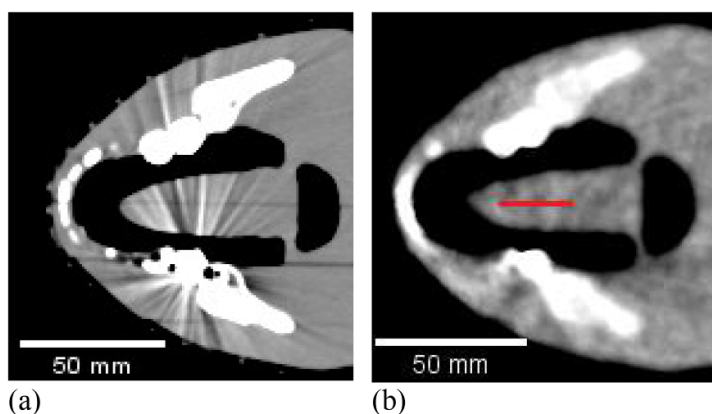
Close-up view, with enhanced contrast, of the tungsten dental filling region: (a) x-CT shown in figure 7; (b) pCT shown in figure 6(a). Red line indicates the ROIs used to quantify the standard deviation of the HU and RSP values.
